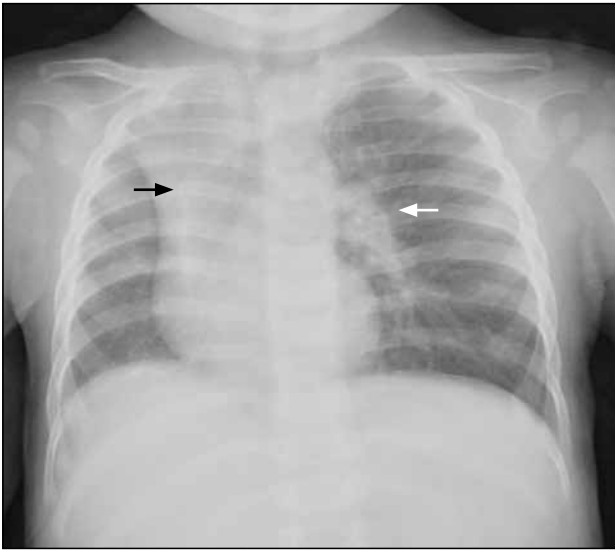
Plain chest radiograph of the first patient. There is volume loss of the right lung with herniation of the left lung to the contra-lateral side (black arrow). The left hilar vessels are prominent (white arrow) while the right hilum is indistinct.
